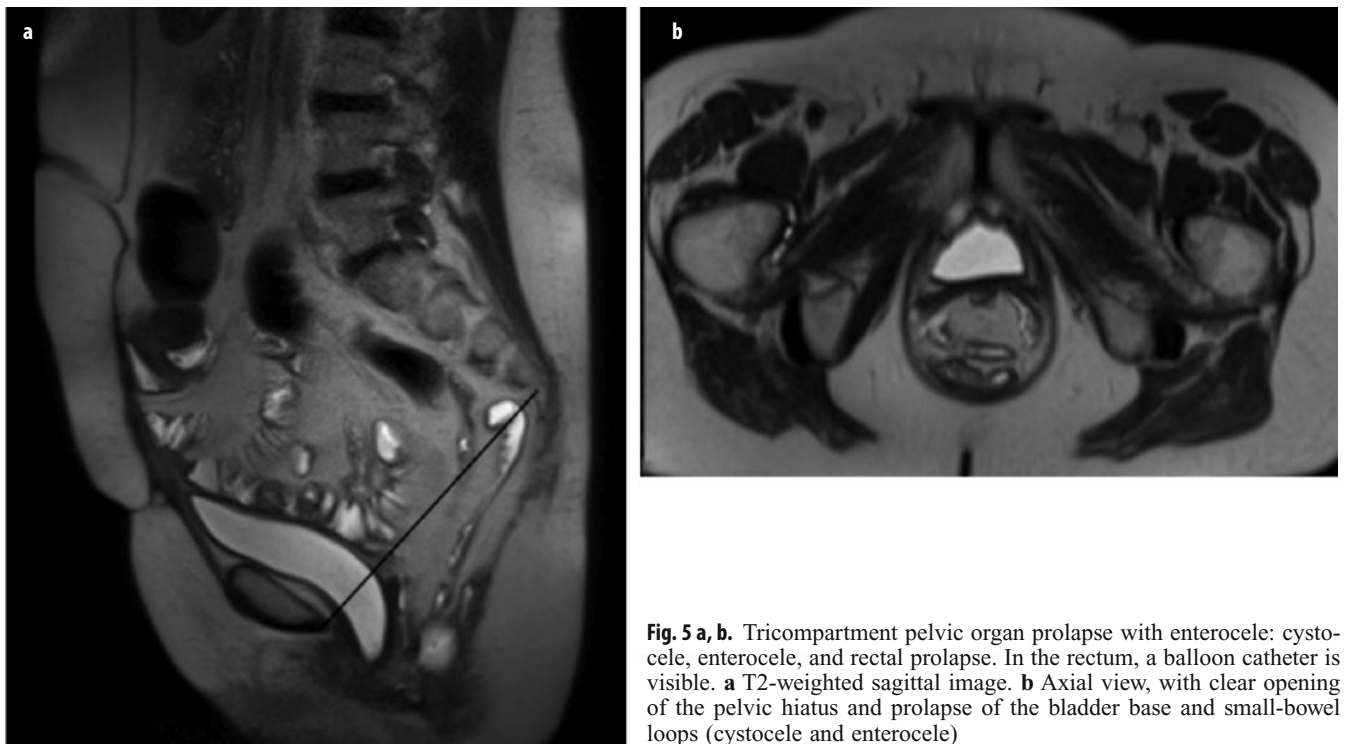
a, b. Tricompartiment pelvic organ prolapse with enterocele: cystocele, enterocele, and rectal prolapse. In the rectum, a balloon catheter is visible. a T2-weighted sagittal image. b Axial view, with clear opening of the pelvic hiatus and prolapse of the bladder base and small-bowel loops (cystocele and enterocele)
